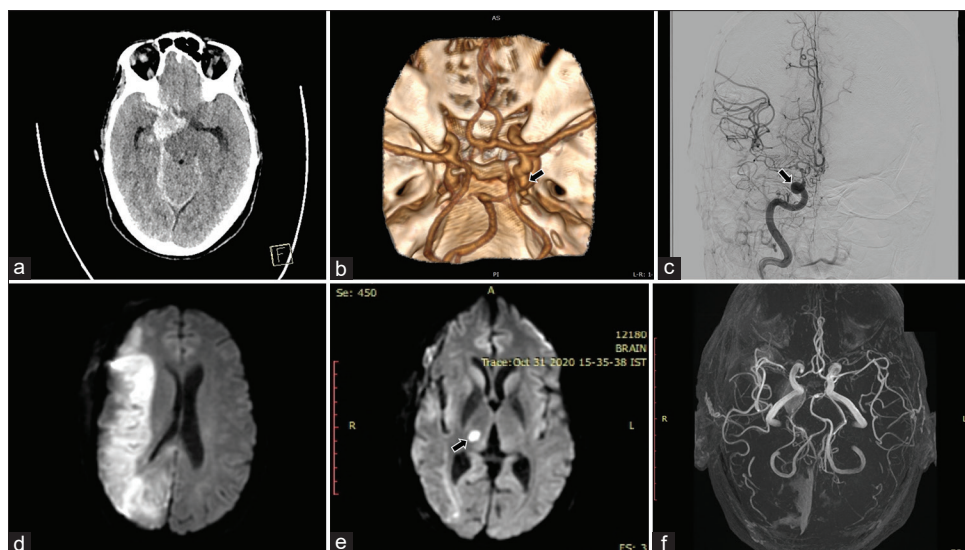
(a) Non-contrast CT head showing thick, diffuse subarachnoid haemorrhage, primarily in right sylvian fissure and basal cisterns (b) Volume-rendering technique 3D reconstruction of the CT angiogram showing a saccular aneurysm (arrow) at the origin of right posterior communicating artery (c) Digital subtraction image (DSA) done preoperatively showing the saccular aneurysm (arrow) at origin of right posterior communicating artery (d) Postoperative MRI diffusion-weighted image (DWI) showing a right internal carotid artery (ICA) territory evolving infarct (e) Postoperative MRI done after 2 weeks showing resolution of the right ICA territory ischaemia, but presence of a right thalamic infarct (arrow) (f) Postoperative MR angiogram image showing obliteration of the aneurysm post-clipping
